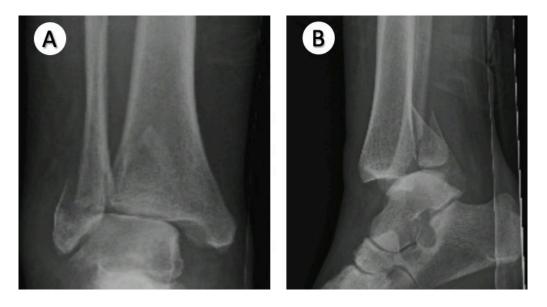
Anteroposterior (A) and lateral (B) radiograph of an obese female patient presenting with an unstable bimalleolar ankle fracture demonstrating evidence of posterior talar dislocation and a large posterior malleolar fracture.
